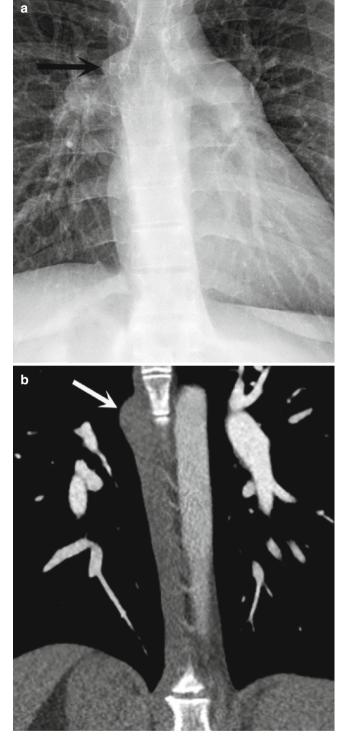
Azygos enlargement in interrupted inferior vena cava. (a) There is a prominent bulge (*arrow*) adjacent to the right tracheobronchial angle. (b) CT confirms a dilated azygos vein in the setting of an interrupted inferior vena cava
